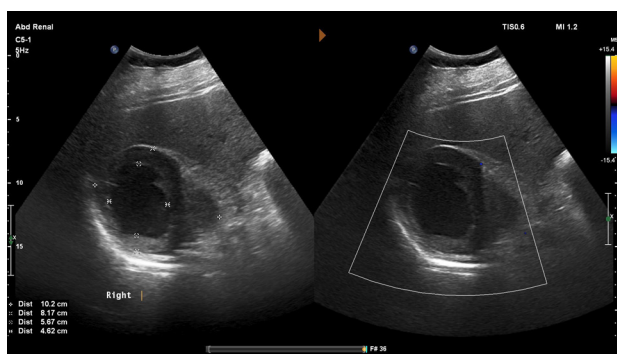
Ultrasonography imaging. Heterogeneous lesion in the right adrenal area with central hypogenic area. Measurements: 10.2 × 8.17 × 5.67 × 4.62 cm
